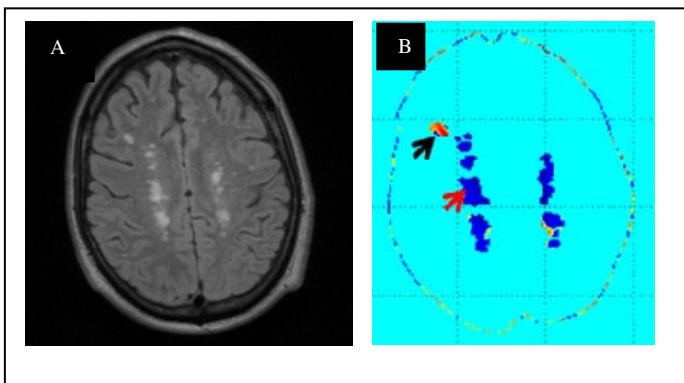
Figure A is a FLAIR image showing regions of high signal intensity in white matter. These hyperintense regions are the lesions seen in patients with VCI. It is proposed that chronic hypoperfusion induced hypoxia due to reduced blood flow to regions of white matter, is the underlying mechanism for the lesions. Additionally, it is postulated that there is increased BBB permeability in these white matter lesions, probably resulting from hypoxic damage. Fig. B shows a color-coded permeability coefficient map for the slice matching the FLAIR image. In the permeability coefficient maps reconstructed using MRI data, pixel signal intensity values are proportional to permeability coefficient values. Pixels with high and low signal intensity correspond to pixels with high (black arrow-top) and low (blue arrow-bottom) permeability coefficient values respectively.
